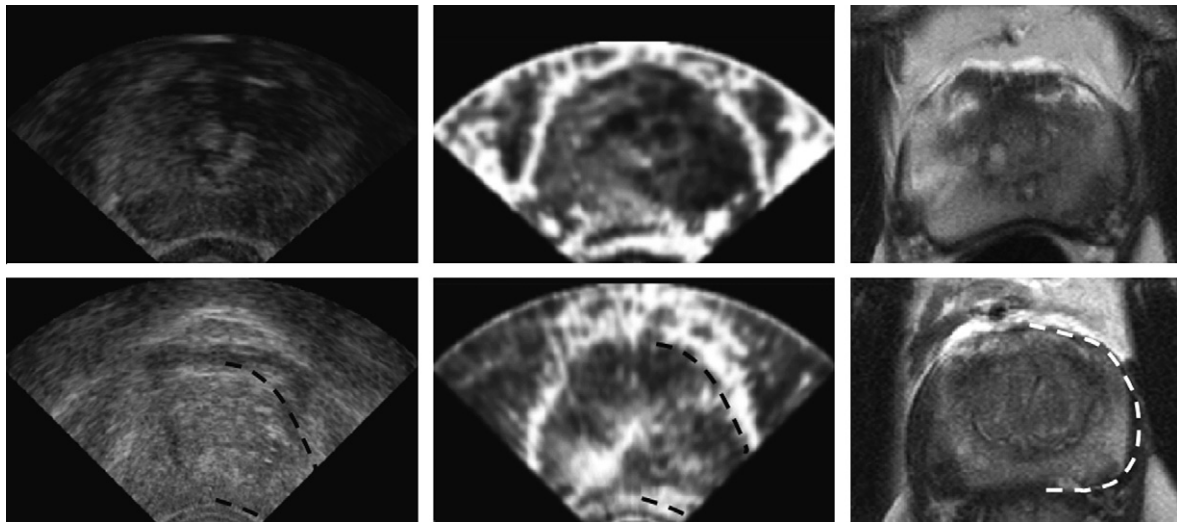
Transverse B-mode (left), VE (middle) and MRI (right) prostate images of two patients. The boundary of the prostate is partially segmented in the second set of images.
